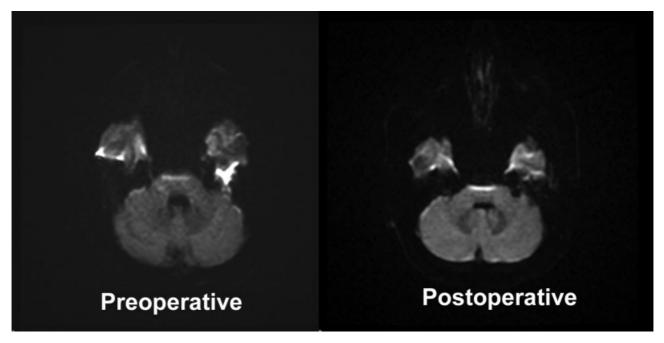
Preoperative and postoperative axial diffusion-weighted magnetic resonance imaging sequences showing complete resection of a left temporal bone and cerebellopontine angle epidermoid tumor.
